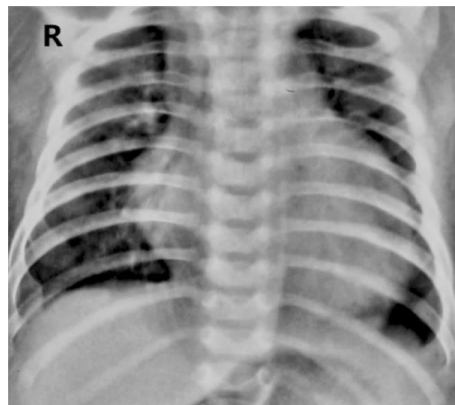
X-ray chest (PA view). Gross cardiomegaly with pulmonary edema was discerned.
